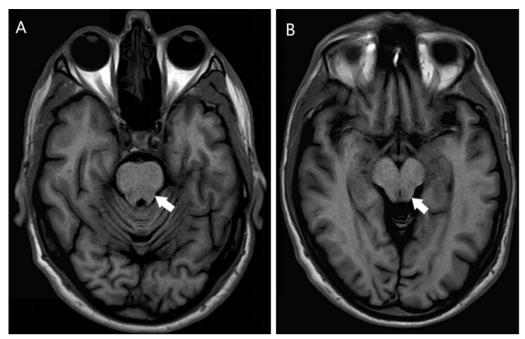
Axial T1-weighted fluid attenuation inversion recovery magnetic resonance imaging sequences. A Patchy hypointensity in the posterior portion of the pons (white arrow). B Hypointensity in the midbrain tegmentum (white arrow)
